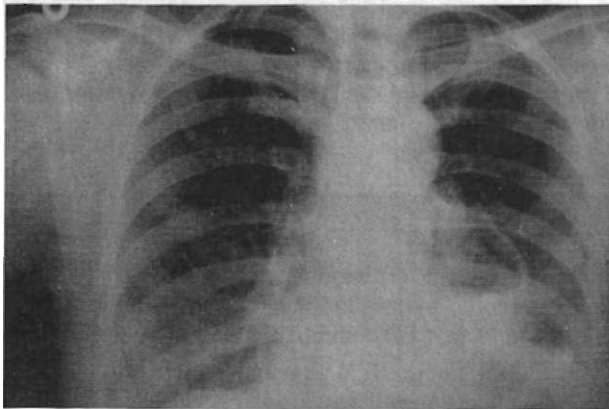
The radiologic appearance of the pulmonary sequestration in the posterioanterior chest radiograph.
